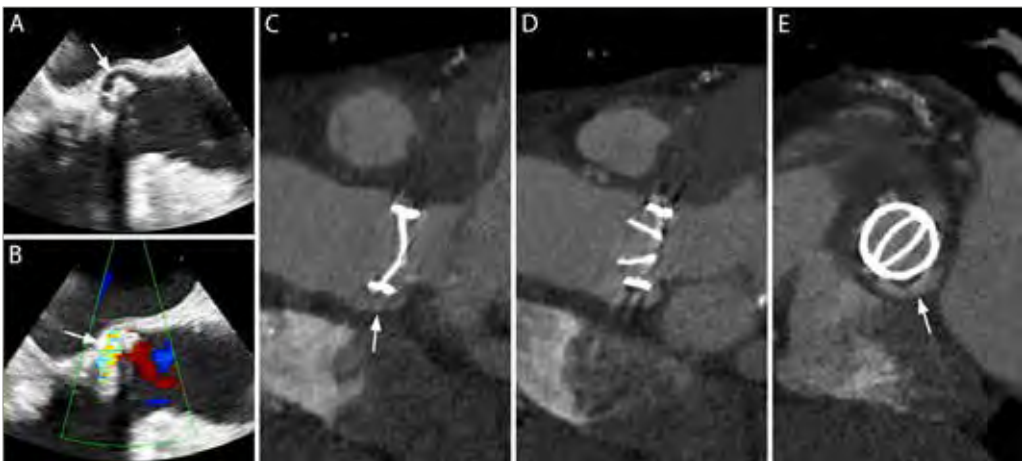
Transesophageal echocardiography (A-B) and CT-angiography (C-E) images of a peri-annular extension (arrow) on the posterior side of an aortic prosthetic valve. The echo-lucent extension fills with contrast on CTA and connects the aorta to the left ventricular outflow tract, as shown by the turbulent and rapid blood flow through the extension on Doppler echocardiography (B).
